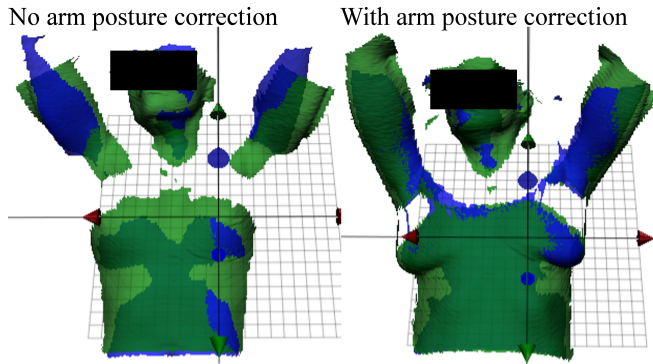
Surface scans for two patients. Live surface (blue) and reference surface (green) from the treatment room and CT room, respectively. A patient without (Patient 31) and with (Patient 12) arm posture correction using the OS-system. Data from CRAM protocol.
